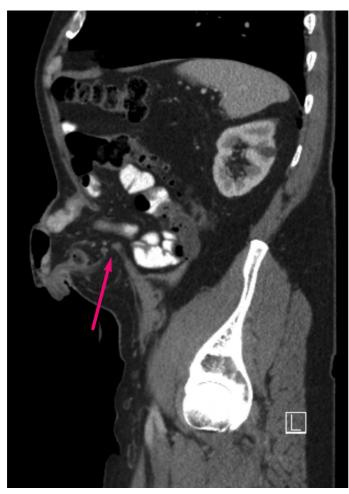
Abdominal CT scan (Sagittal plane) Arrow shows parastomal hernia
